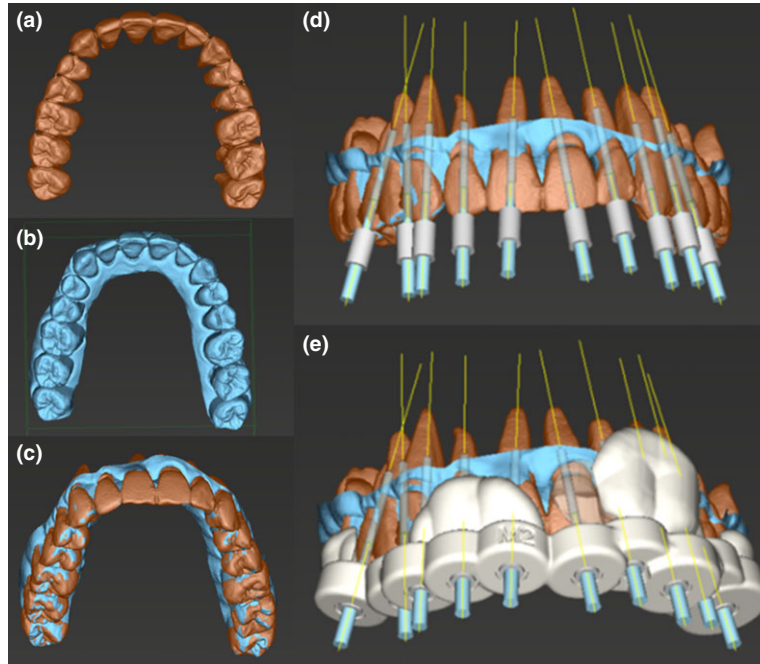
Matching of CBCT and surface scans: (a) CBCT scan (b) surface scan (c) matched scans (d) superimposition of virtual bur (e) designed template including sleeves and burs.
